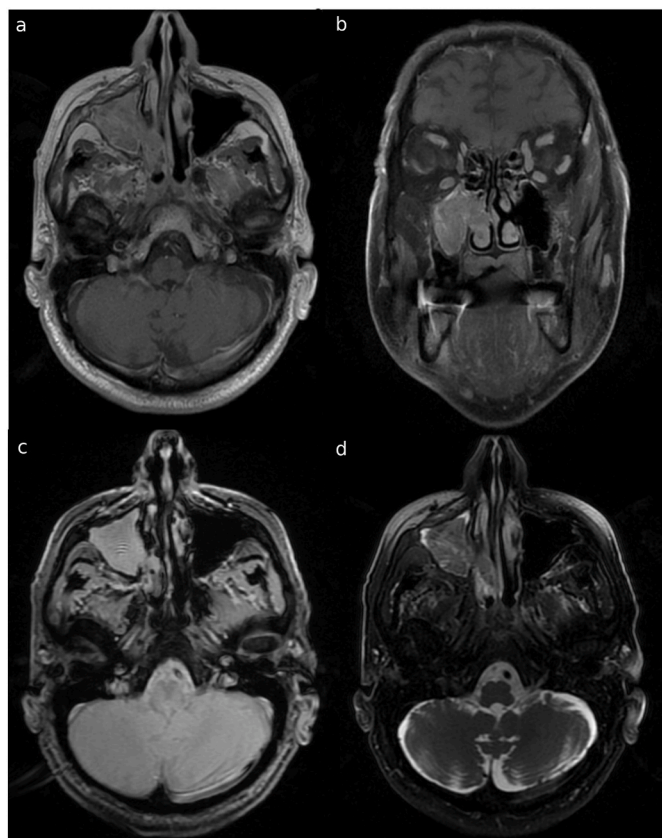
MRI of maxillary sinus showing the presence of a pathological soft tissue extending into the right nasal choana with no intra-cranial extension, showing intermediate signal intensity on T1 sequence (a: axial, b:coronal, c: axial, d: axial).
